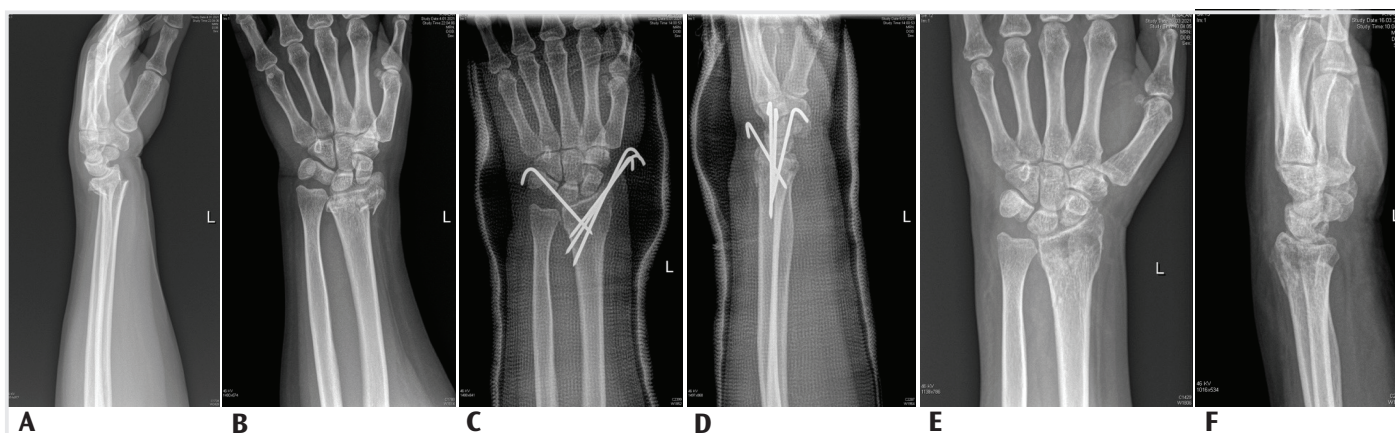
Displaced distal radius fracture operated with isolated radial pinning technique. (A) Preoperative anteroposterior X-ray. (B) Preoperative lateral X-ray. (C) Early postoperative anteroposterior X-ray. (D) Early postoperative lateral X-ray. (E) Postoperative 12th week anteroposterior X-ray. (F) postoperative 12th week lateral X-ray
